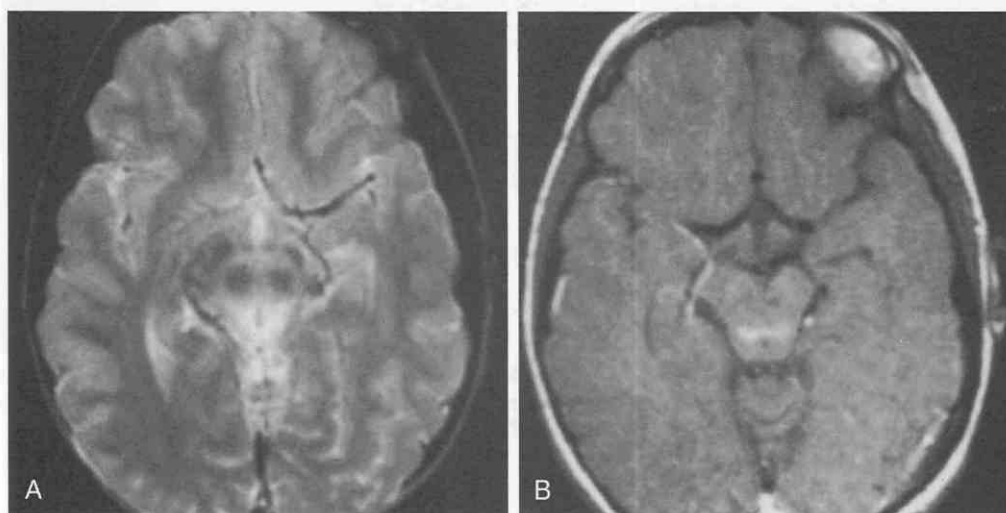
Leigh's disease (subacute necrotizing encephalomyelopathy) in a 10-year-old girl with developmental delay and slow neurologic deterioration. A and B, Initial MR scans. C and D, Follow-up scan 3 years later. A, T2-weighted axial MR image at the level of the midbrain. Hyperintensity of the entire mesencephalic tectum is visible, with lesser involvement of the cerebral peduncles. B, Postgadolinium-enhanced, T1-weighted image at the same level demonstrates symmetrical enhancement just anterior to the aqueduct.
